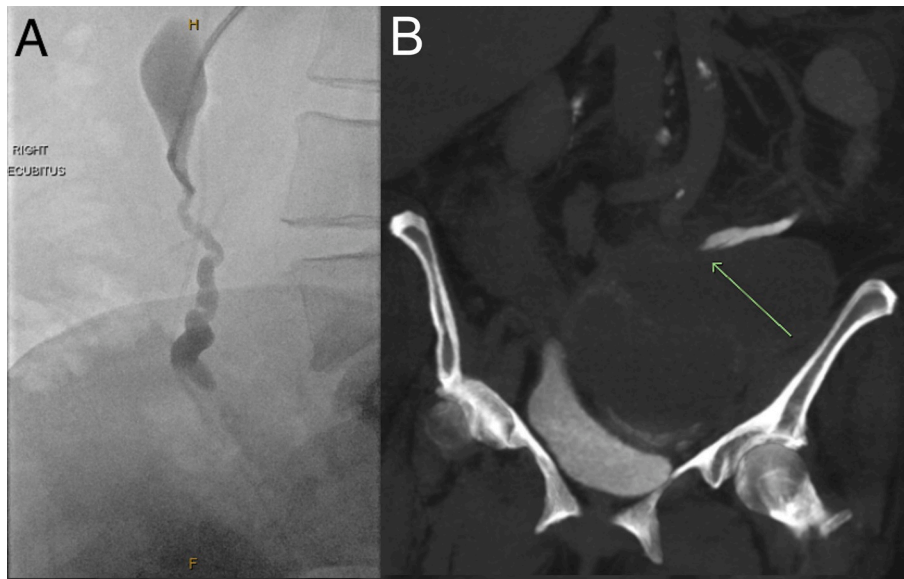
Left: Nephrostogram, lower moiety, demonstrating abrupt cessation of flow at pelvic brim. Right: CT IVP demonstrating point at which lower moiety ureter abruptly ceases and large associated urinoma.
